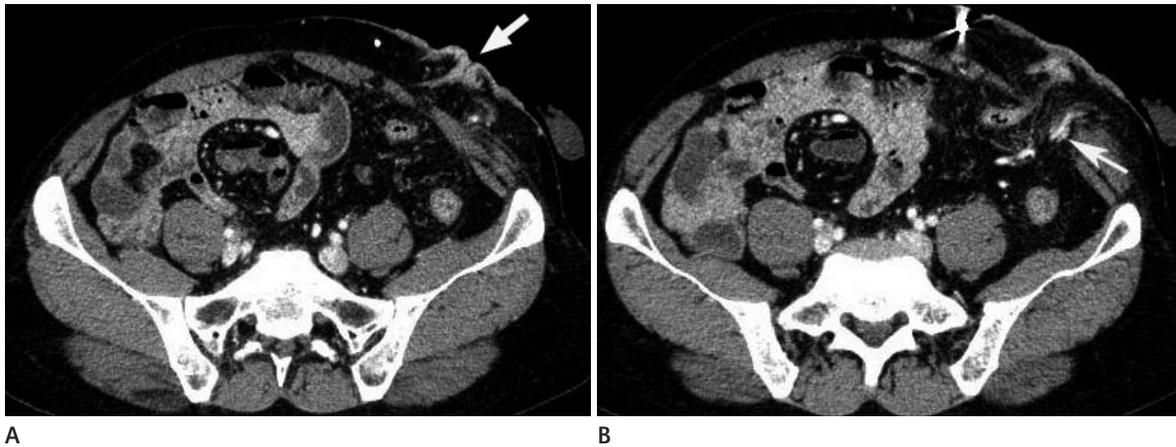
Computed tomography of abdomen (A, B) shows stomal varix at left lower quadrant abdominal wall and inflow vein (arrow in B) arising from inferior mesenteric vein (IMV). Reconstructed CT angiogram (C) shows varix (arrowheads), inflow vein from IMV (white arrow) and out flow vein drain to left femoral vein (black arrow).
